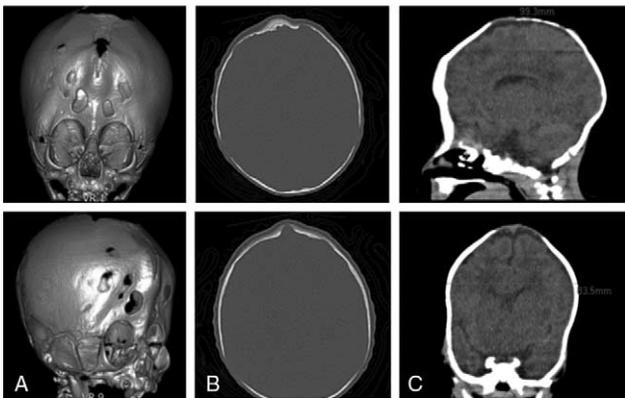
Preoperative computed tomography. (A) Three-dimensional reconstruction. (B) Axial view showing omega sign and metopic synostosis. (C) Coronal and sagittal view showing decreased intercoronal distance and small ventricles.
